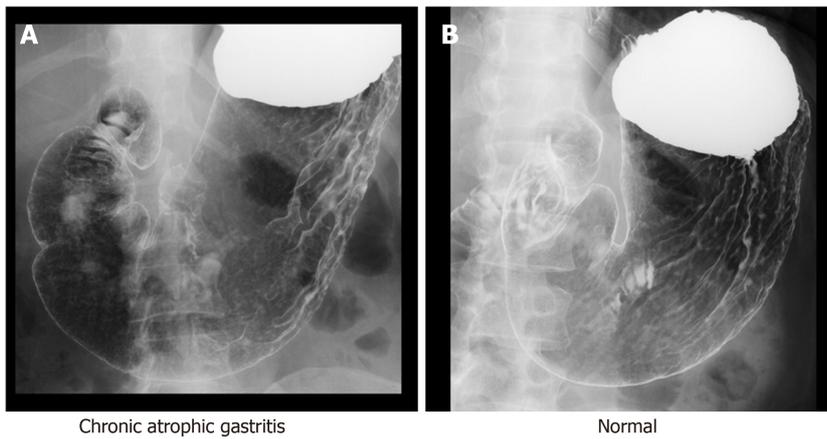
Examples of gastric X-ray images for evaluation.
